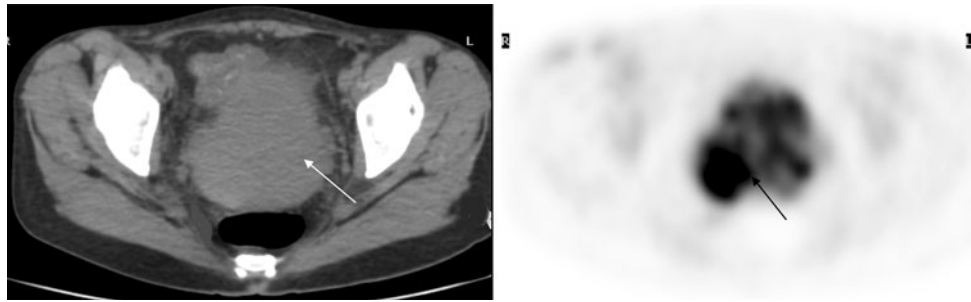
Invasive cervical cancer in a 44-year-old woman with AIDS. Transaxial images of FDG PET-CT show a large bulky endocervical mass with intense uptake (SUV 15). There is parametrial and upper vaginal extension
